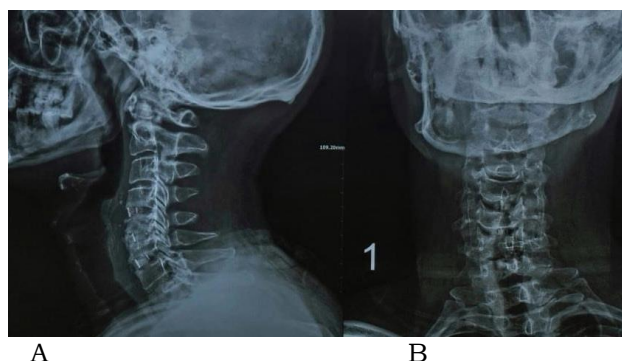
Follow up x-ray (12 months), A) AP view, B) Lateral view showing excellent fusion.
